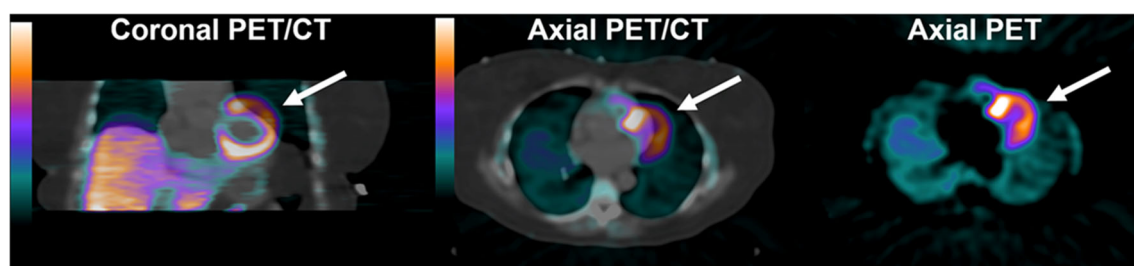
Example of cardiac PET/CT perfusion exam with PET and CT misalignment. The CT acquisition was performed at a location in the respiratory pattern with more inspiration than the average location
